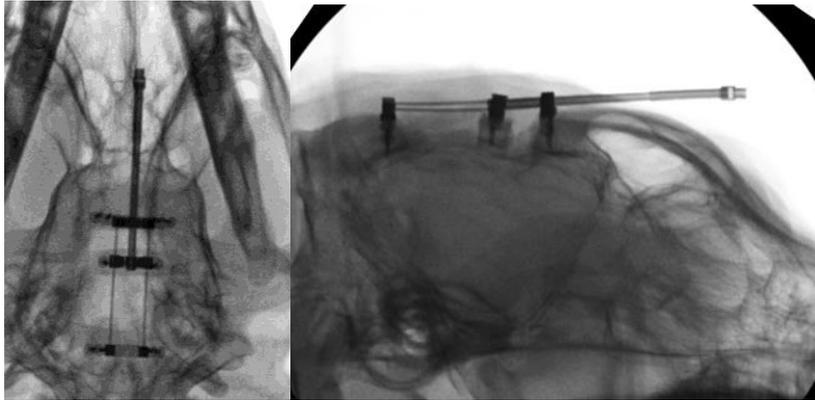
Plain X-ray at the end of distraction. Position change or deformation of distraction device was checked by this study.
